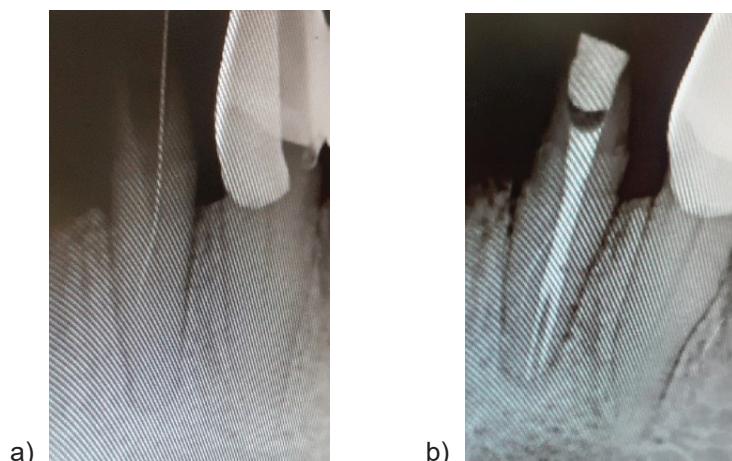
a, b. X-ray images of complications during a two-week endodontic treatment from a wrong approach to the conical part of the root. Between the visits the bone and root resorptions, total periodontitis with acute symptoms appeared and were treated with conservative methods
